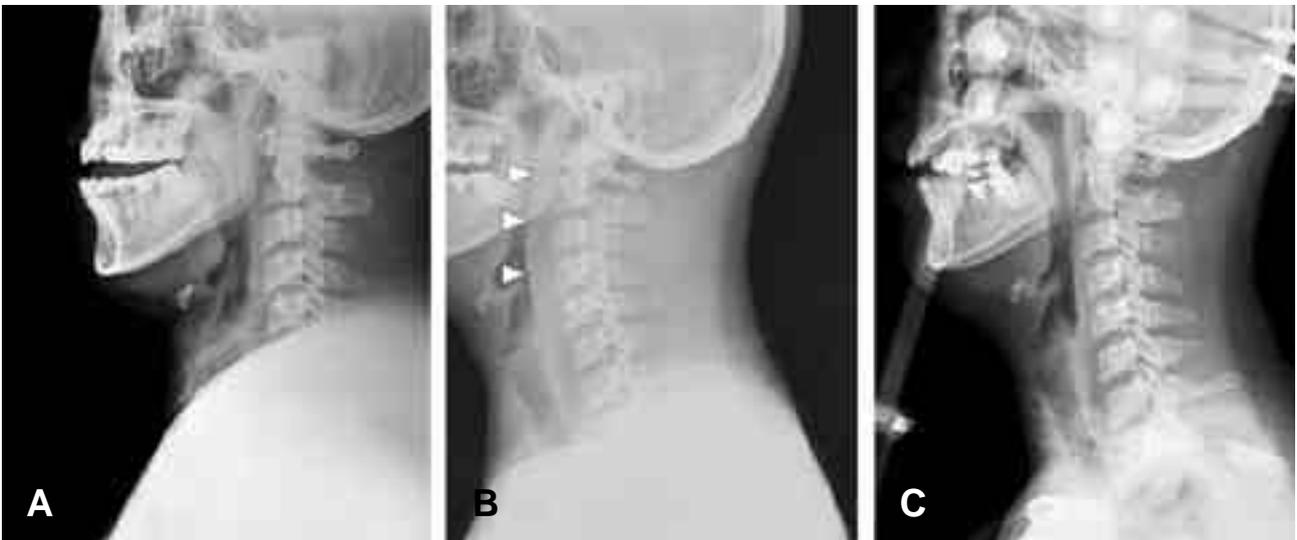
Soft tissue view of lateral neck x-ray film. Initial film shows fracture on spinous process of C1. Widening of retropharyngeal space is not marked (A). There is diffuse soft tissue swelling of the retropharynx (arrow heads) at HD#2 (B). Almost normal width of retropharyngeal soft tissue at HD#21 (C).
